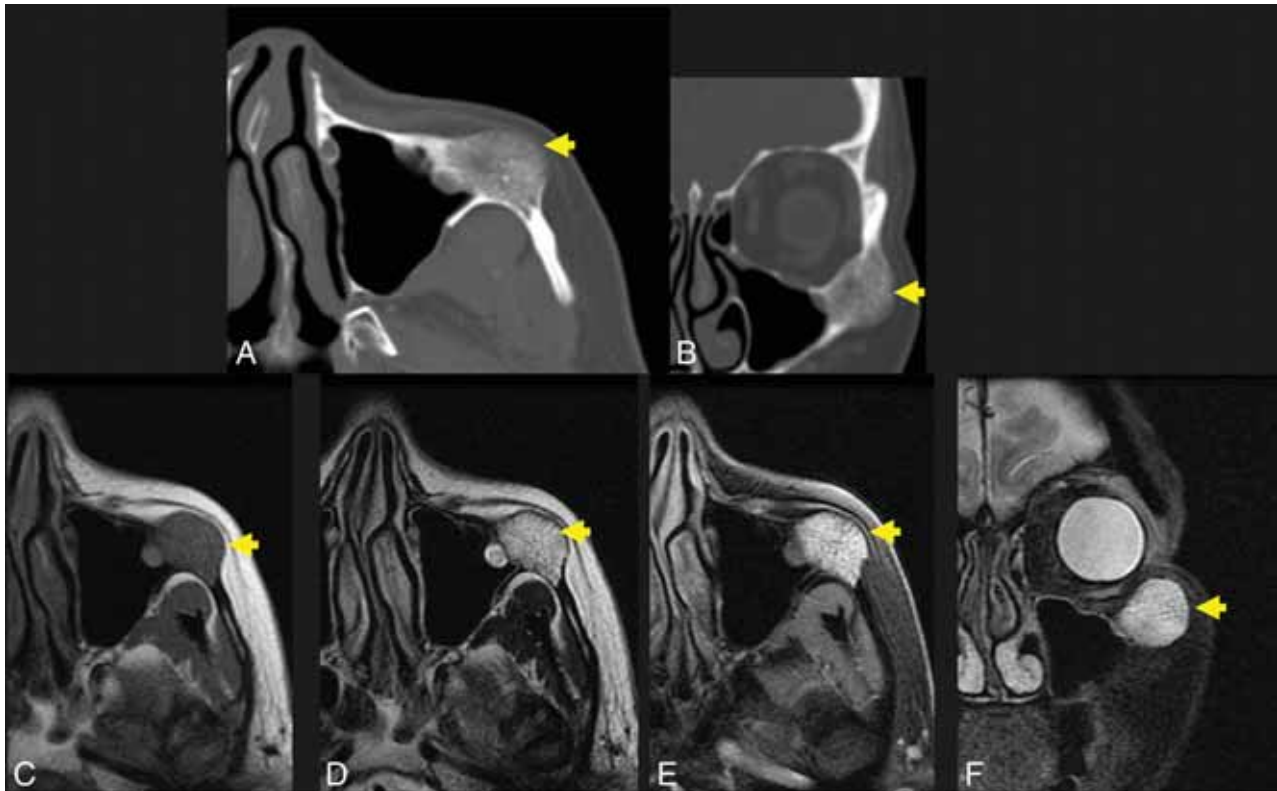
A 56-year-old woman with a palpable facial mass. The *yellow arrow* indicates a lesion in A–F. Axial (A) and coronal (B) thin-section CT in bone windows demonstrates an expansile, low-density lesion with internal coarsened trabeculae. The characteristic internal honeycomb pattern is typical of an IOVM. Axial T1 C– (C) and axial T1 C+ FS (D) sequences demonstrate a T1-intermediate, avidly enhancing lesion that extends beyond the cortical margin; the cortex is thinned but identifiable. Axial T2 FS (E) and coronal T2 FS (F) sequences demonstrate that the lesion is markedly T2 hyperintense. The diagnosis of IOVM was made on the basis of the characteristic imaging appearance, and the lesion remained stable on surveillance imaging for 3 years. C+ indicates with contrast; C–, without contrast.
